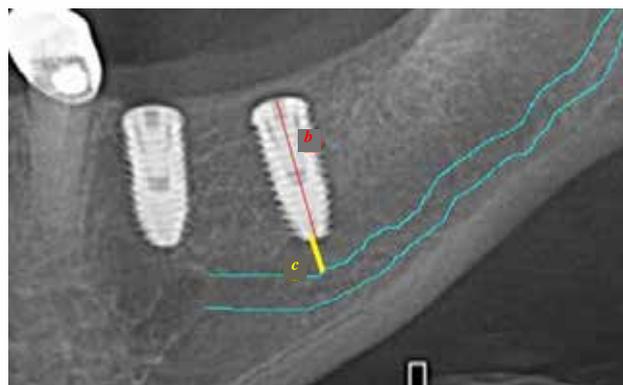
Radiograph to measure not actual length of transplant (b), and the distance between the implant apical tip and the upper wall of the mandibular canal (c).
